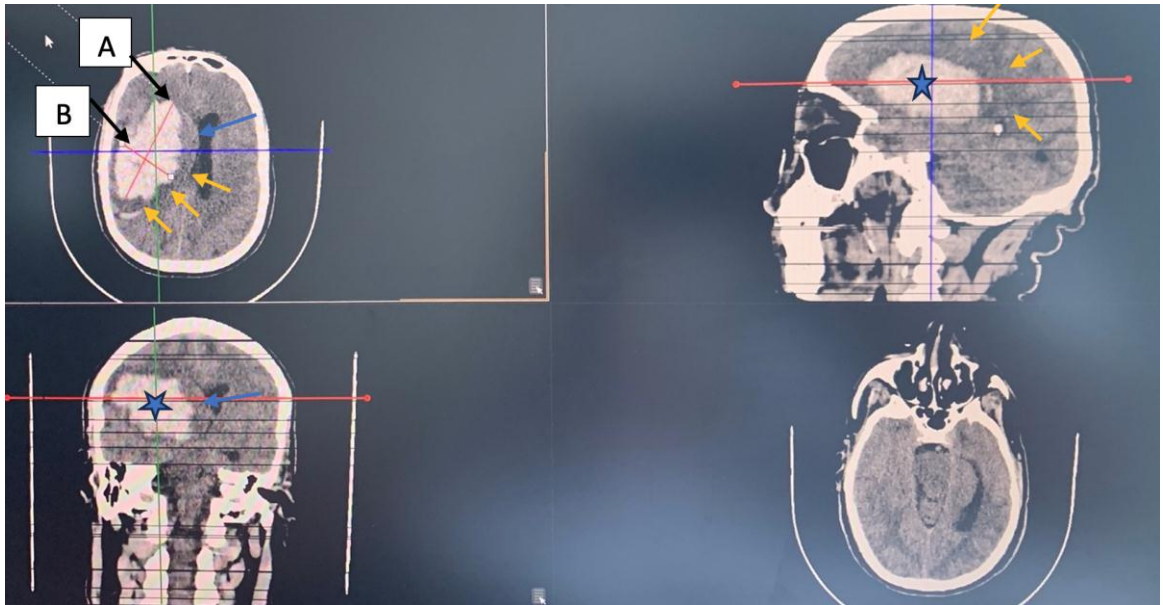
Multiplanar non-contrast Brain CT images of a 62 yr M with frontal-parietal ICH (blue star), perihematomal edema (yellow arrows), mass effect and midline shift (blue arrows).
